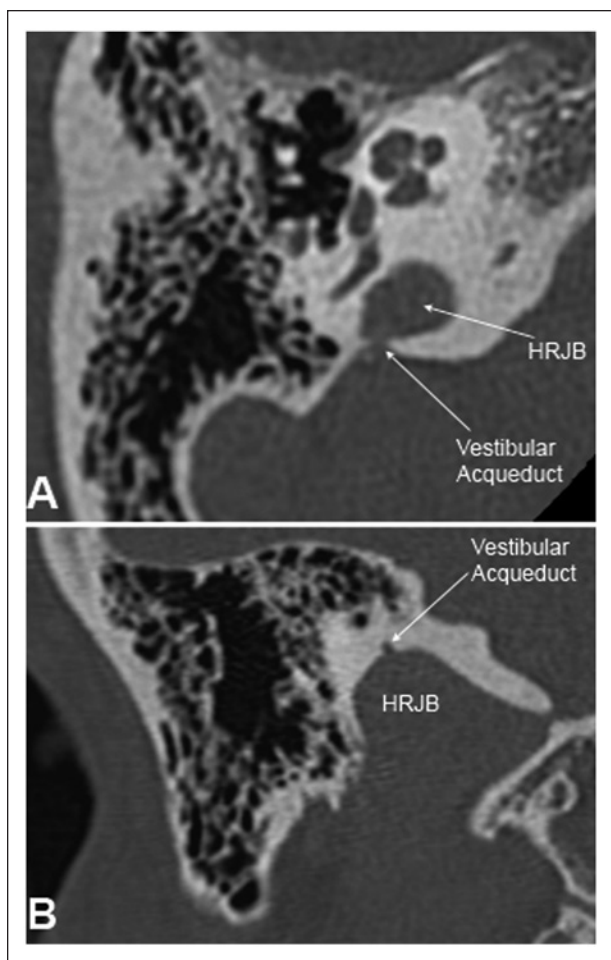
Patient 2: Right temporal computed tomography scan showing a high-riding jugular bulb (HRJB) and dehiscence of the vestibular aqueduct (A, axial view; B, coronal view).
